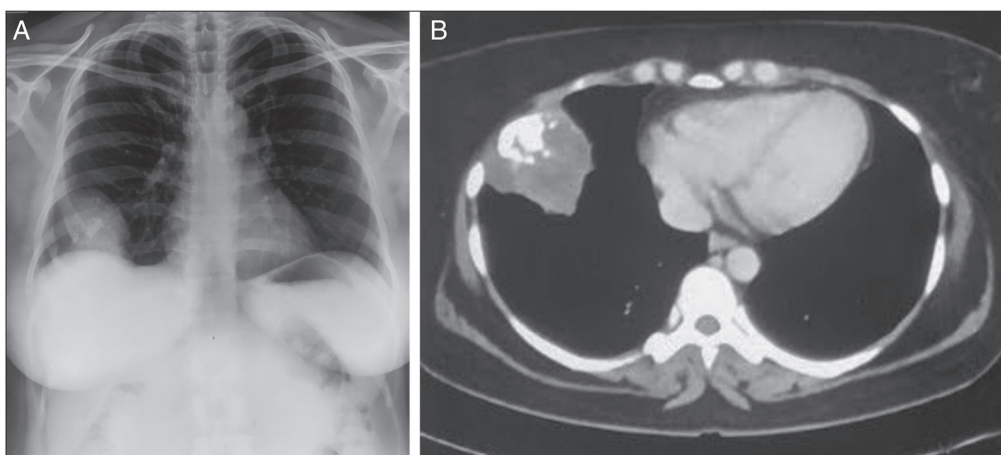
(A) Chest X-ray PA view showing homogenous opacity in the right lower zone. (B) CECT thorax showing mass arising from the sixth rib with intra-tumoral calcification resembling intrathoracic mass
